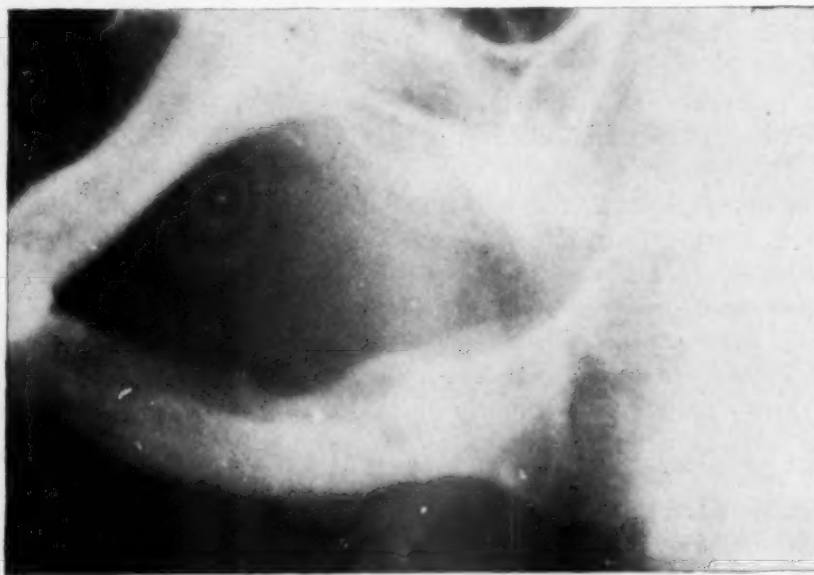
Postoperative x-ray showing wire removed and mandibular canal repaired.
